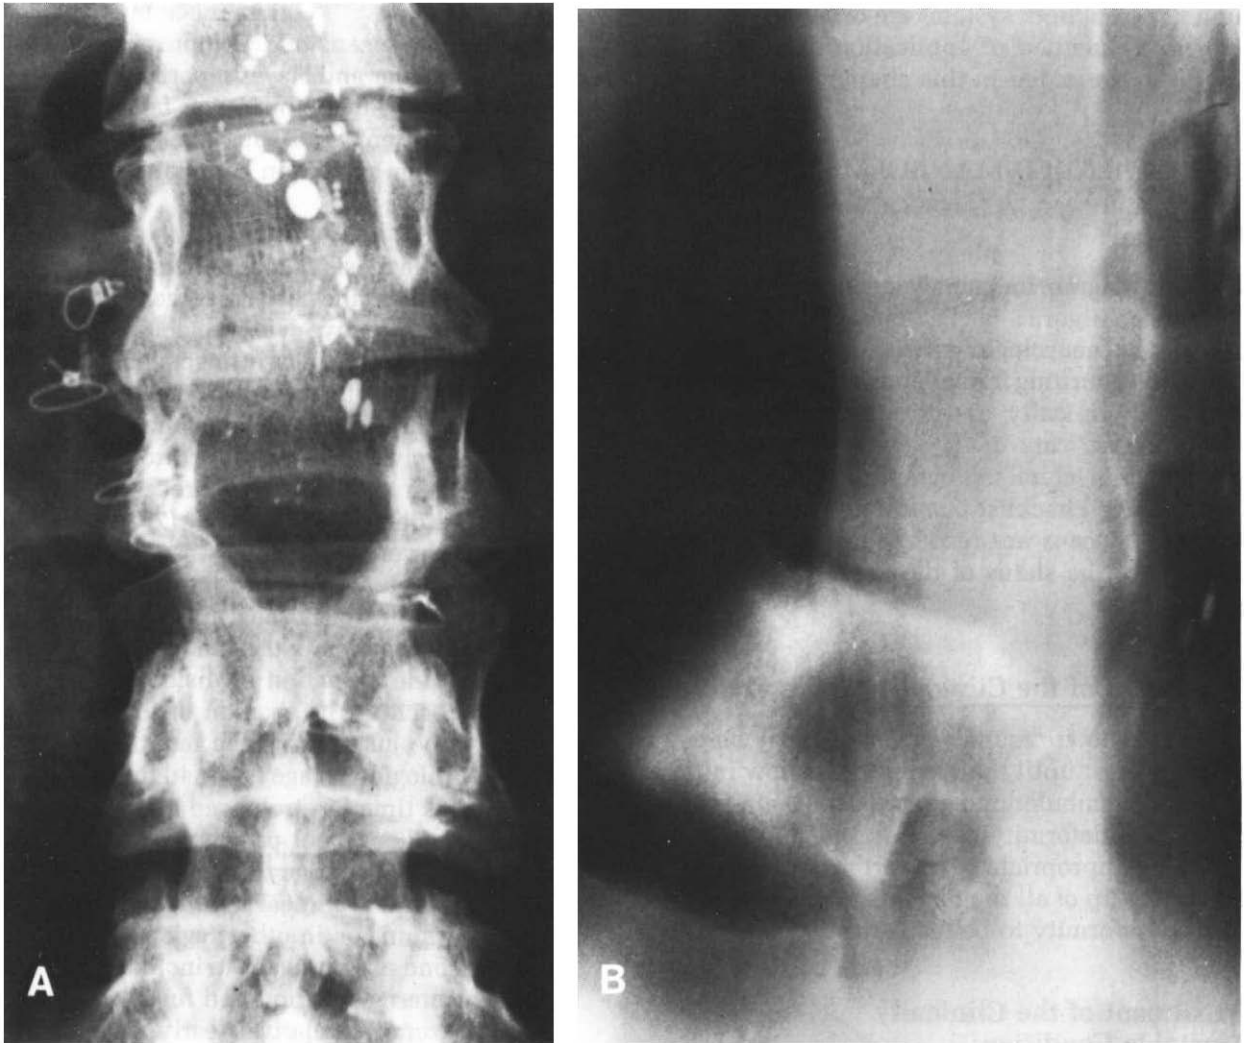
Radiographs of a patient with clinical instability of the lumbar spine. (A) A wide laminectomy at L2, L3, and L4. (B) Abnormal posterior displacement of L2 on L3. In addition to surgery of the posterior elements, this patient also shows removal of the disc, which disrupted the stability anteriorly.
